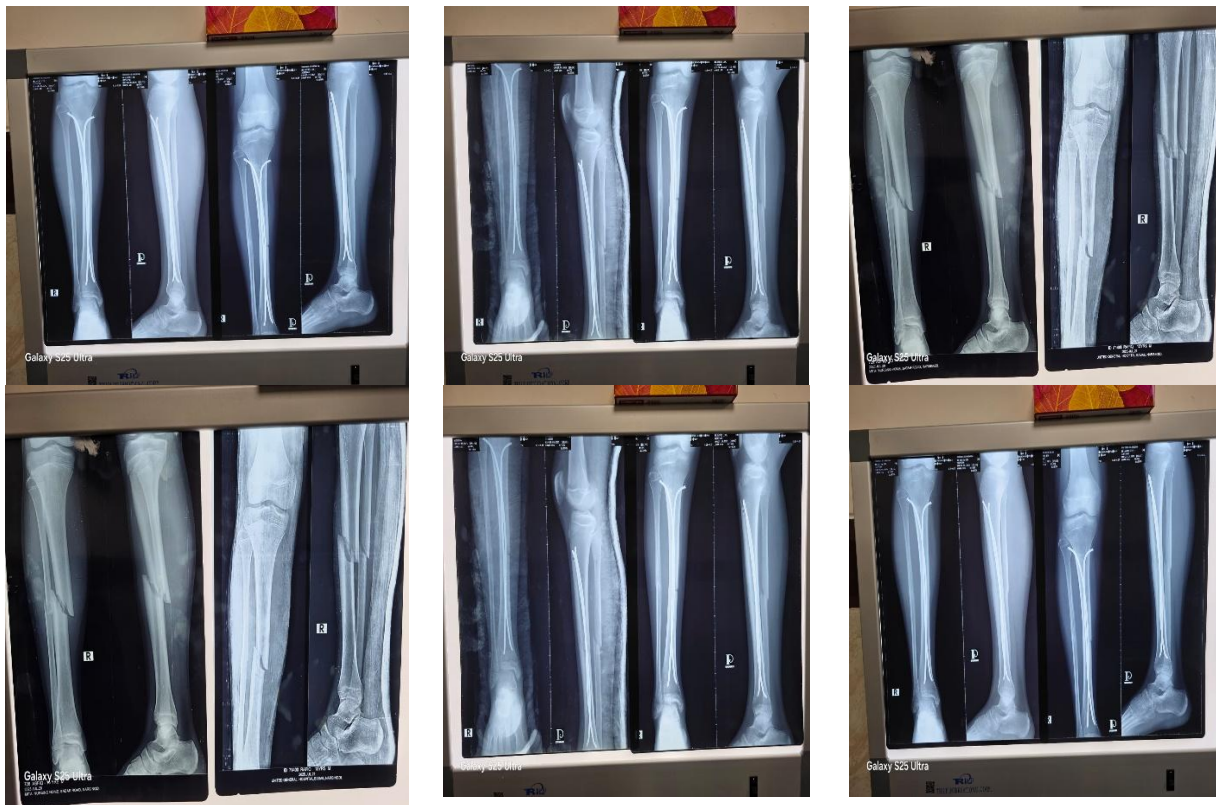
Radiographic Evaluation of Pediatric Tibial and Fibular Shaft Fractures Managed with Titanium Elastic Nailing System (TENS).
